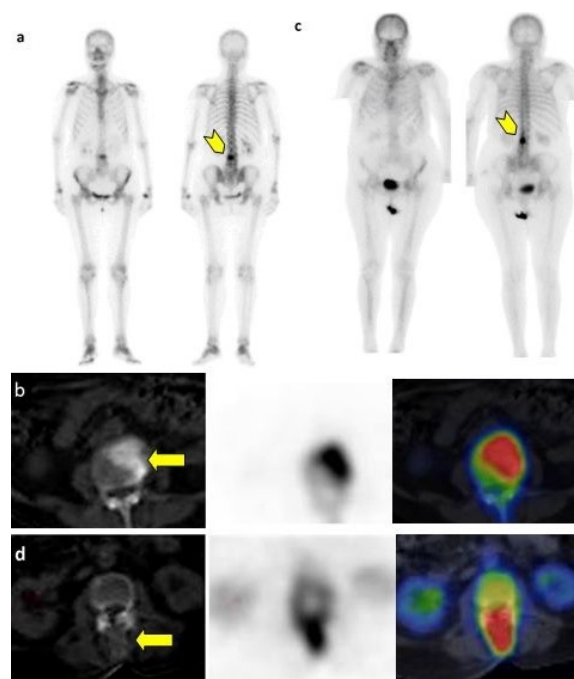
Two patients with similar WBS images but different SPET/CT findings. The first is a 65 years old female with ductal BC stage IIB at the time of the diagnosis, complaining of low back pain of recent onset. WBS (a) exhibited intense focal tracer accumulation at the lower lumbar spine (arrow head). The study was interpreted as suspicious for metastases. After SPET/CT (b) the aforementioned finding was attributed to L3-L4 intervertebral disc degeneration (arrow). The second is an 82 years old patient with ductal carcinoma referred for a bone scan because of tumour marker elevation. Like the previous example, suspicious WBS findings were focused on the lumbar spine (arrow head). In this case SPET/CT revealed a large osteolytic lesion at the spinous process of L3 vertebra (arrow) (d).
